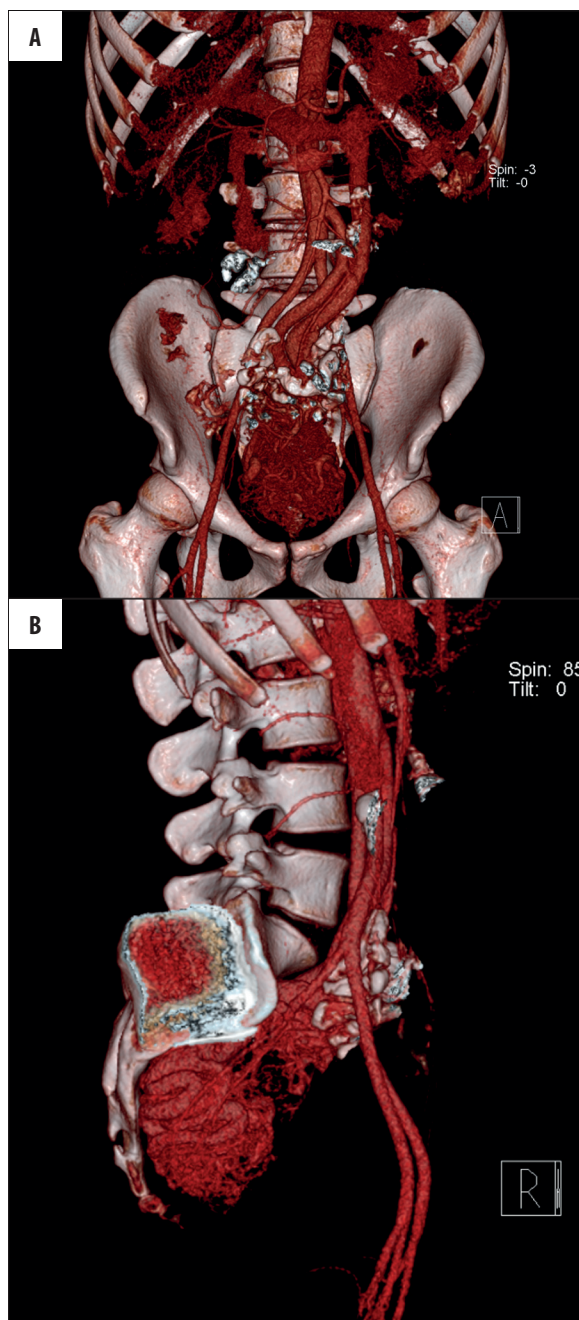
CT examination, VRT reconstructions, anterior (A) and right-hand view (B): visible arteriovenous malformation filling a considerable part of the small pelvis.
